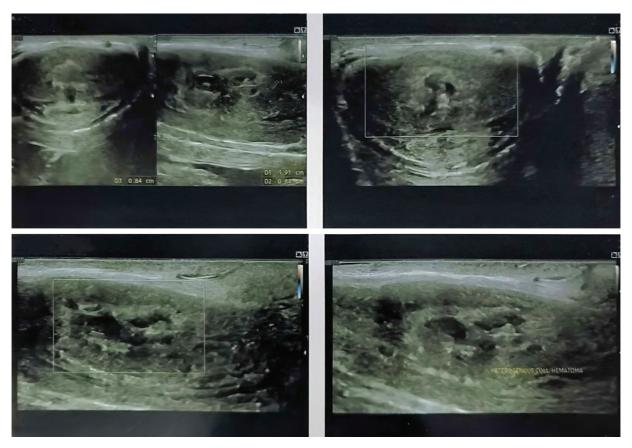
The ultrasonography scan revealed a hyperechoic lesion of chronic hematoma collection.
